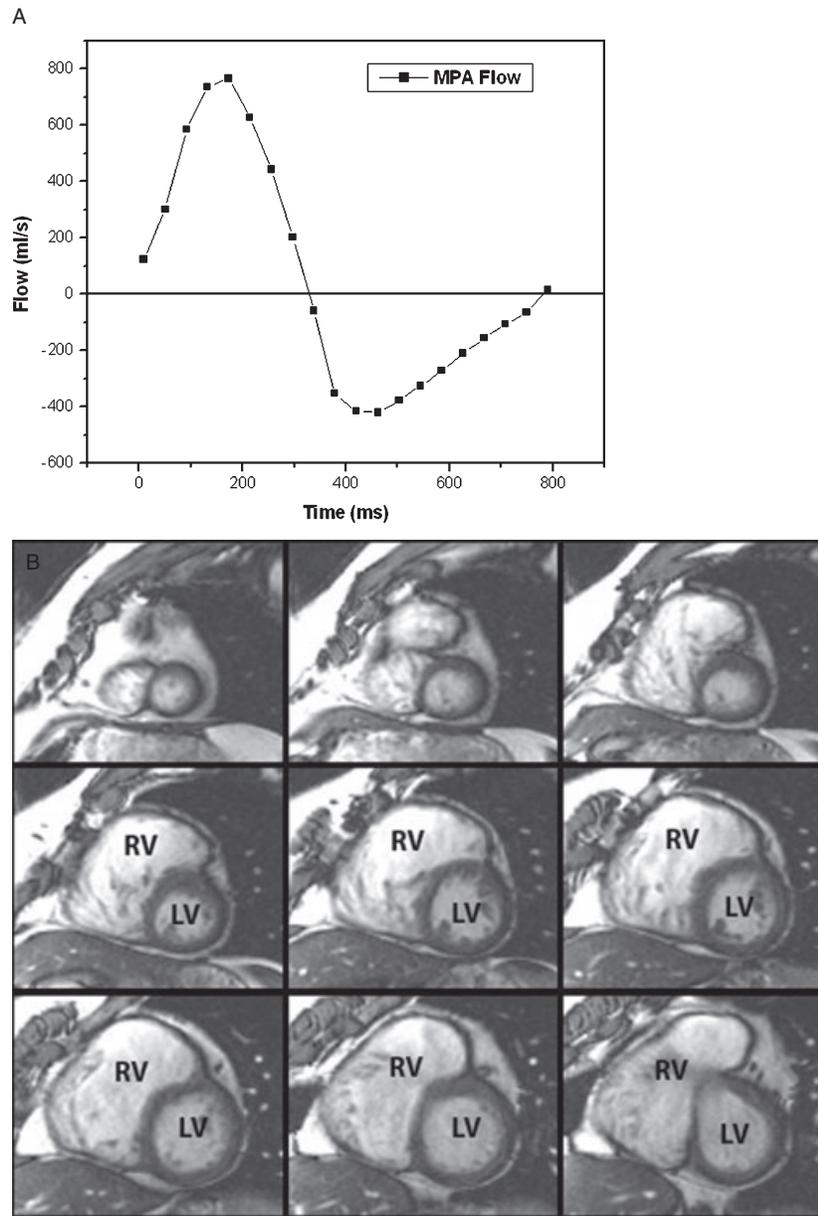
Phase contrast cardiac magnetic resonance imaging provides an accurate method of evaluation of (A) velocity, volume, and the pattern of blood flow that allow accurate measurement of both systolic and diastolic pulmonary artery flow and calculation of pulmonary valve regurgitation fraction. (B) Cardiac magnetic resonance imaging is also a reliable technique for assessing right ventricular size and function. MPA indicates main pulmonary artery; LV, left ventricle; RV, right ventricle.
